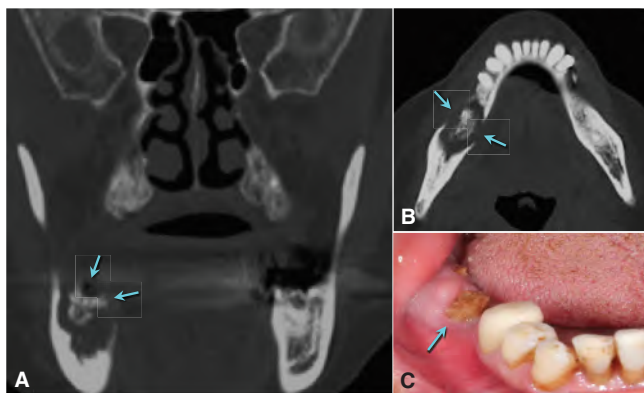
A case of medication-related osteonecrosis of the jaw in an 83-year-old woman who was taking a bisphosphonate drug for osteoporosis therapy for 6 years. A. Coronal CBCT view shows an ill-defined radiolucency of the right side of the mandible with internal opacity (blue arrows), characteristic of free-floating necrotic bone or “sequestrum.” B. Axial view shows erosion or perforation of the buccal and lingual plates (blue arrows) along with the central sequestrum formation. Note contralateral uninvolved mandible. C. Clinical image of the same patient showing exposed necrotic bone (blue arrow) in the oral cavity. Diagnosis of such cases can only be made in conjunction with accurate medical history and clinical factors linked to bisphosphonate drug history. (Courtesy of Dr. Parish P. Sedghizadeh, Los Angeles, CA.)
